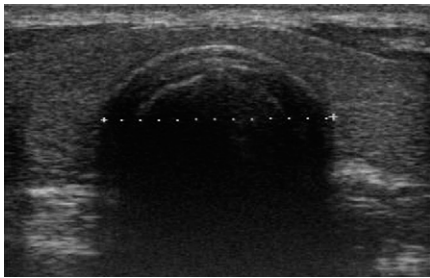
Transversal ultrasonographic section of the trachea. Ultrasonographic measurement of outer tracheal width is presented.
